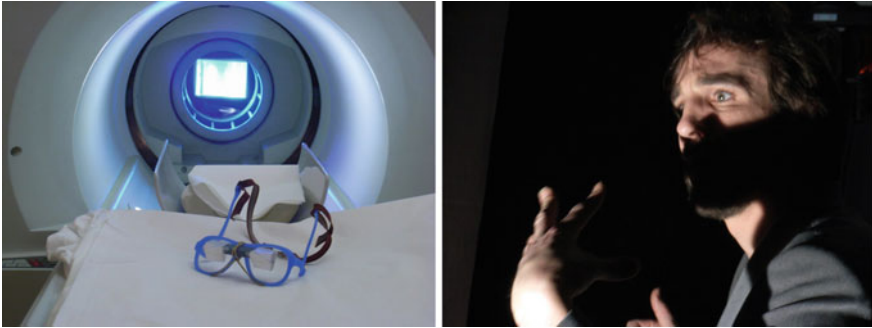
Left* MRI scanner and internal broadcasting dispositive. *Right* An image of a theatrical event selected from the play
